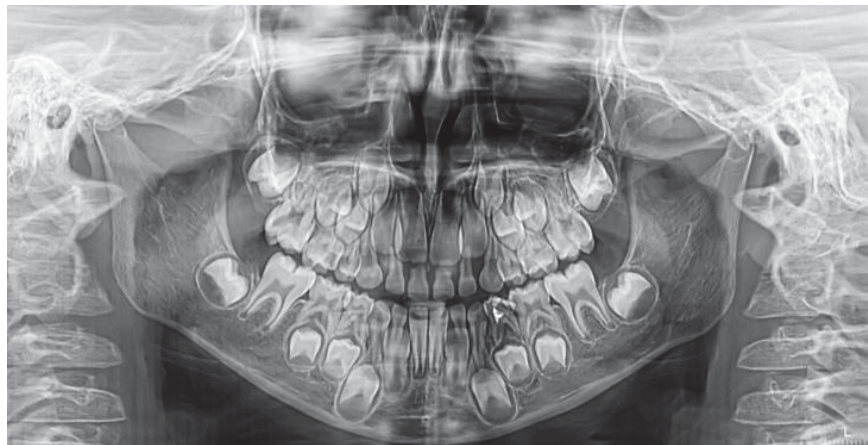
Orthopantomography
